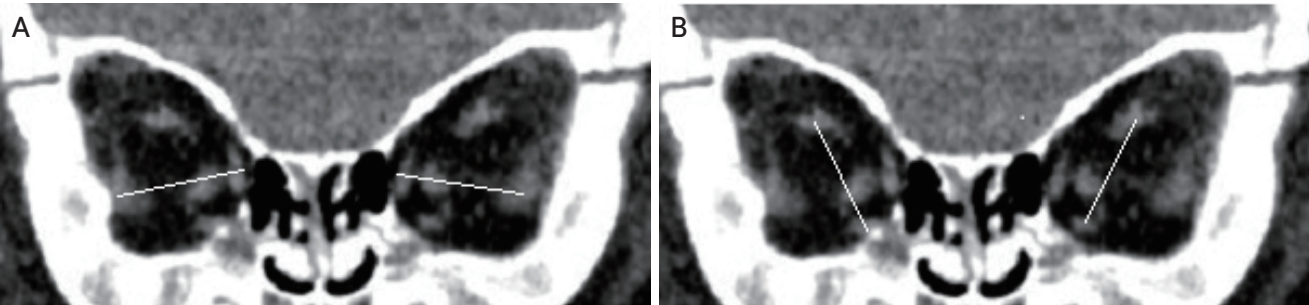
Coronal views on computed tomography scan showing lateral displacement of the superior rectus muscle and downward displacement of the lateral rectus muscle. (A) A horizontal line joining the center of the belly of the horizontal rectus muscles. (B) A vertical line joining the center of the belly of the vertical rectus muscles.
